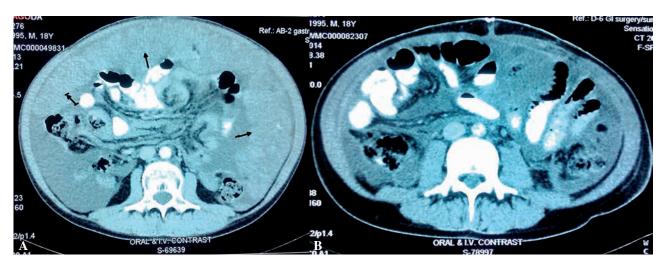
A. Axial contrast enhanced CT scan showing nodular omental thickening (arrows) with ascites. B. Axial contrast enhanced CT scan after treatment (surgery and chemotherapy) shows mild ascites with complete resolution of the soft tissue mass.
